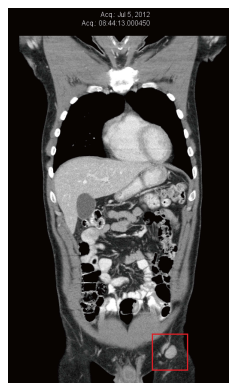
Computed tomography scan from July 2012 after 3 mo of natural therapy alone, just prior to the start of dichloroacetate therapy. Largest node measured 22 mm × 20 mm.
